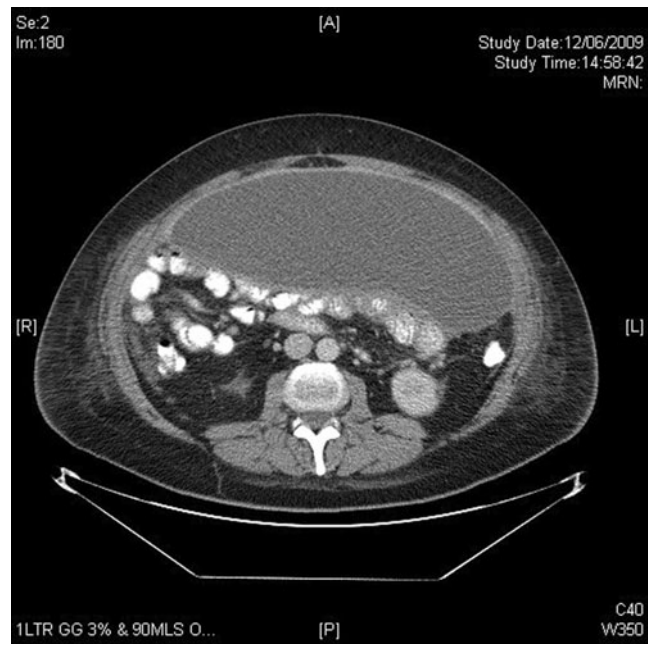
CT scan after drainage of ascites.
